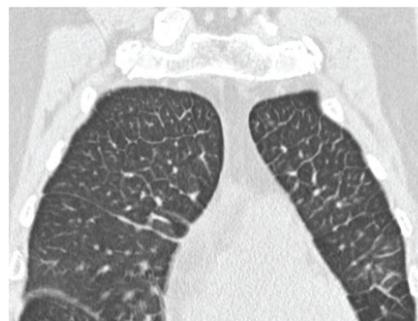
Coronal HRCT image showing smooth interlobular septal thickening outlining the secondary pulmonary lobules. Bilateral involvement favour pulmonary edema. Patient was in renal failure.
